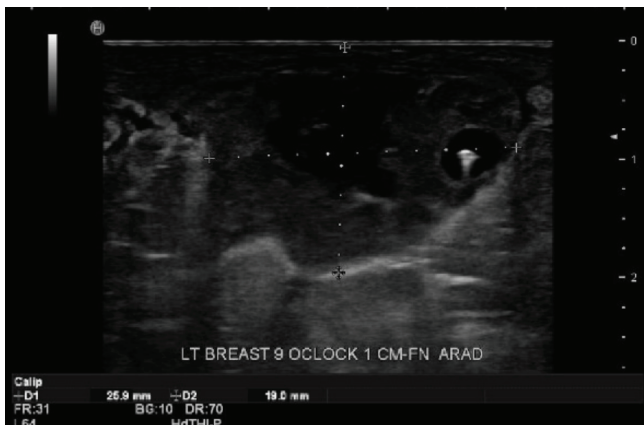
Ultrasound image of left breast mass after core biopsy, prior to start of treatment (hypoechoic mass measures 26 x 19 x 21 mm)
